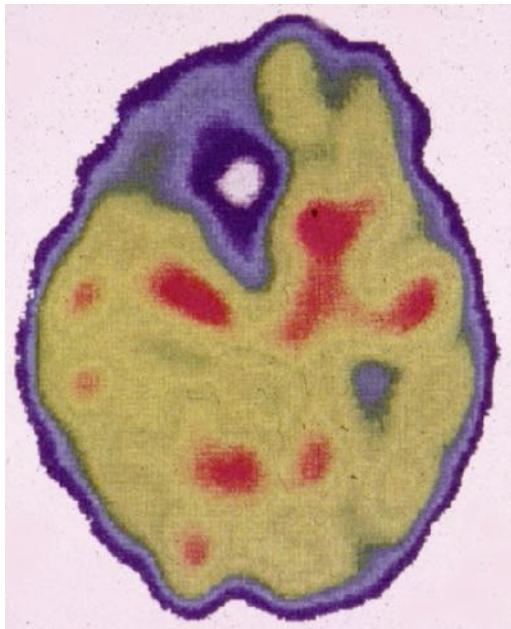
SPECT scan of "The Man Who Borrowed Cars."³⁵ By permission from Elsevier.
